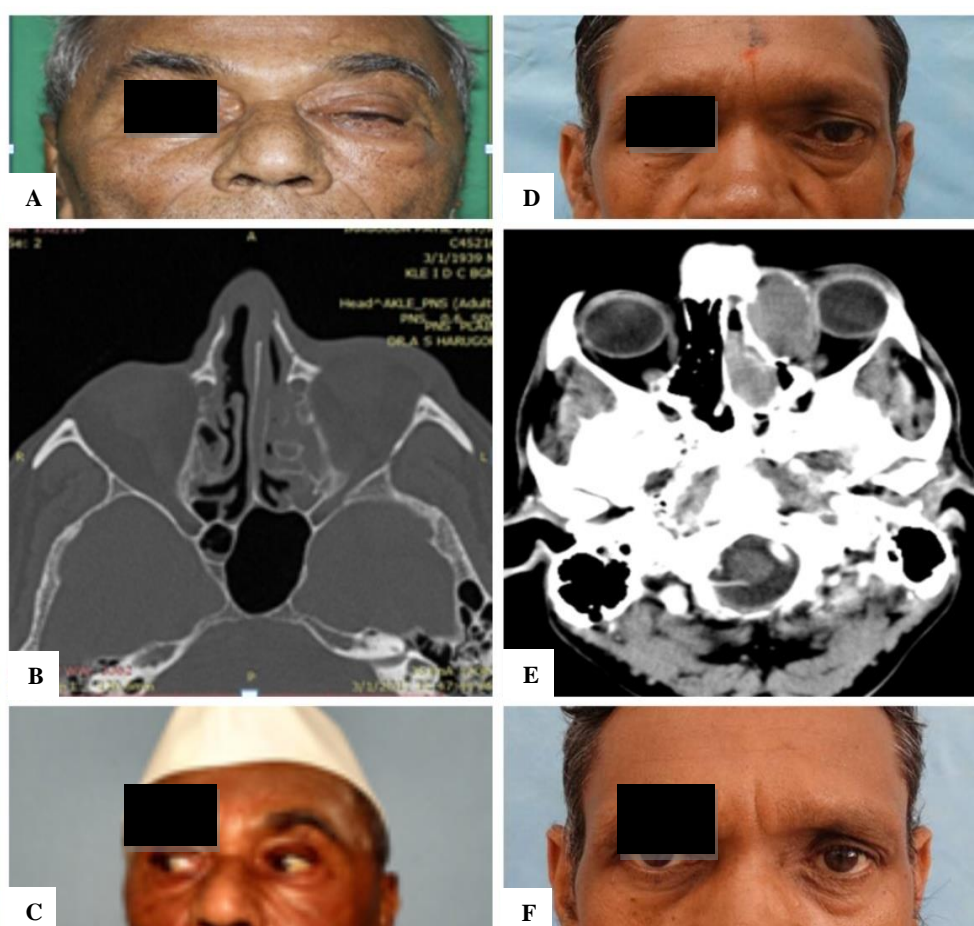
(A) Preoperative picture of a fungal sinusitis patient who presented with proptosis and eyelid oedema; (B) CT picture of ethmoid sinusitis with orbital involvement; (C) Postoperative picture of complete recovery; (D) Preoperative picture of a patient of mucocoele who presented with headache and proptosis; (E) Contrast enhanced CT showing mucocoele with diffuse extension in to orbit; (F) Postoperative picture after endoscopic surgery along with marsupialisation of cyst wall. Patient had immediate recovery.
